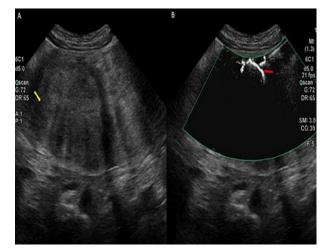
Ultrasound of abdomen and pelvis showing large heterogeneous soft tissue mass occupying the superior epigastric and mid abdomen extending to the lower abdomen (Yellow arrow) with feeding vessel seen in the periphery in super microvascular imaging technique (Red arrow).
